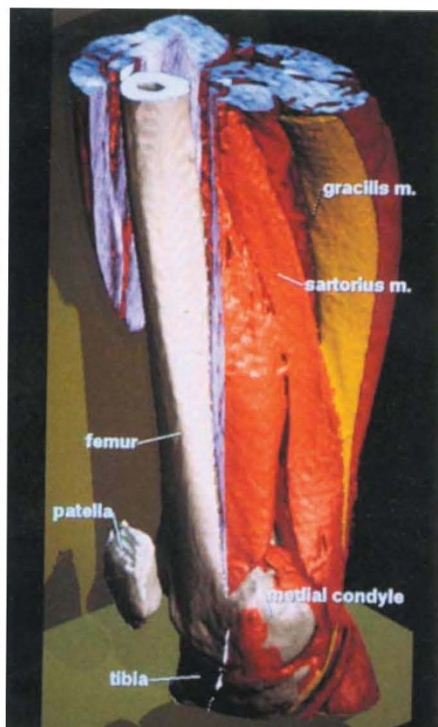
View generated with the 3D interactive atlas of the musculoskeletal system derived from computed tomography.
